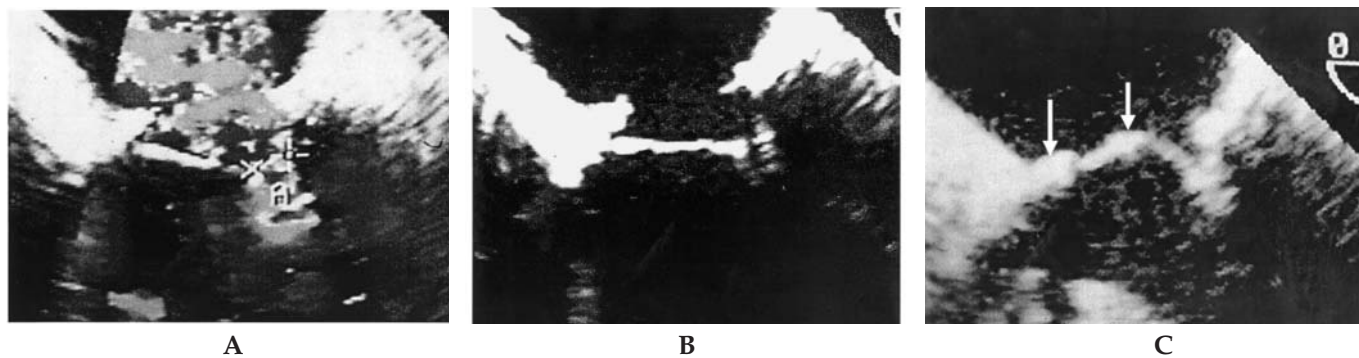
A) Color Doppler showing massive residual insufficiency after valve repair with prosthetic ring annuloplasty alone. B) Persistent restriction due to leaflet and chordae retraction resulting in a central lack of coaptation in spite of a downsized annuloplasty. C) Result following a re-repair using anterior leaflet augmentation with autologous pericardium. There is a large surface of coaptation. Note that most of the native anterior leaflet is displaced towards the ventricle and serves for coaptation.
